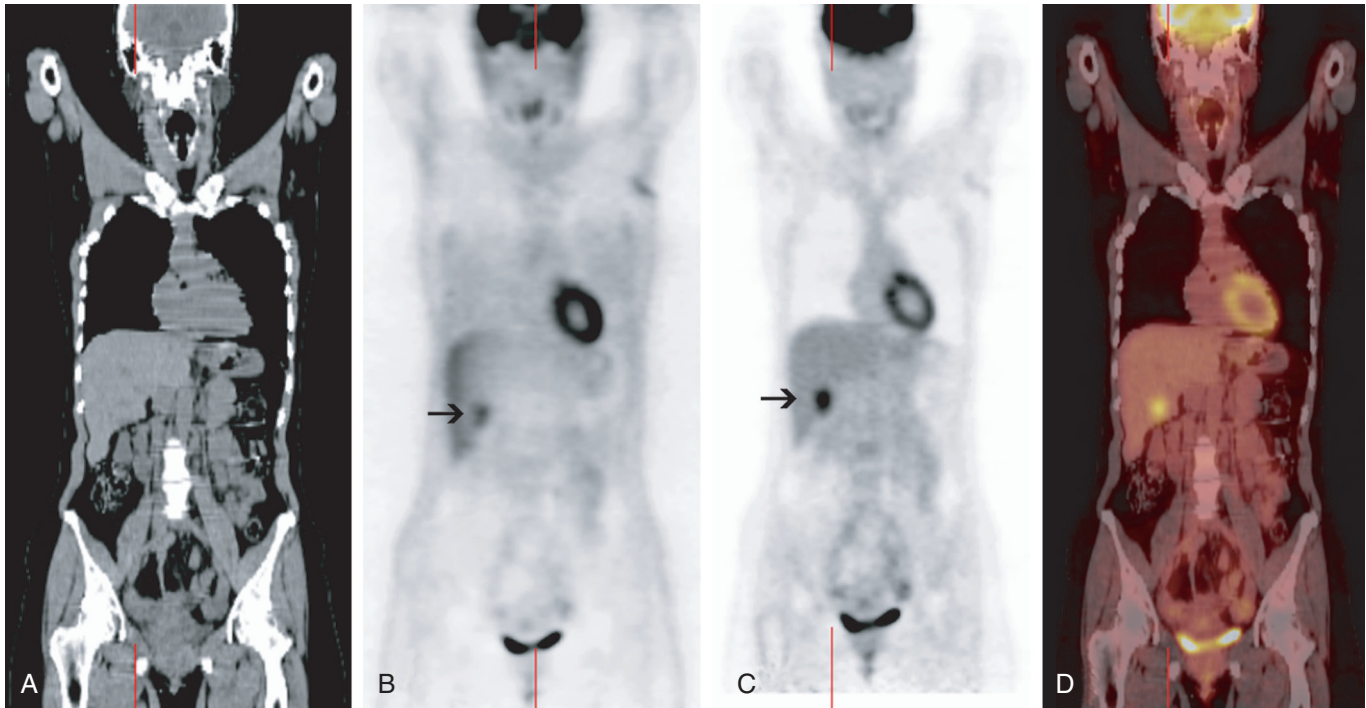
CT (A) provides diagnostic information (morphology), anatomic localization (D), and photon attenuation data to equalize the intensity of uptake between deeper and superficial structures on the PET scans. In this example, the metastatic liver lesion (arrow) is better appreciated on the attenuation-corrected PET image (C) than on the nonattenuation-corrected PET image (B).
